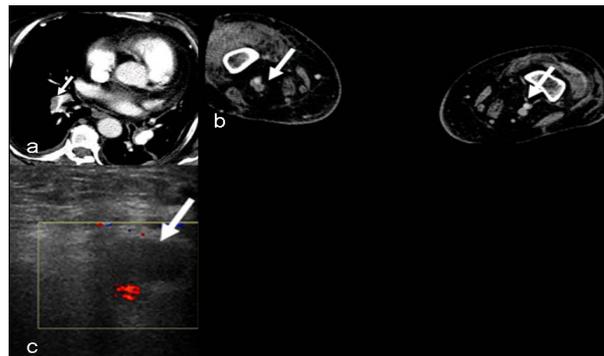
Case 2. A. Filling defect in the descending segmentary branch of the right pulmonary artery (arrow) in pulmonary CTA B. Hypodense filling defect in the right popliteal vein in indirect CTV. Left popliteal vein is normal C. Thrombus in the right popliteal vein in Doppler Ultrasound.
